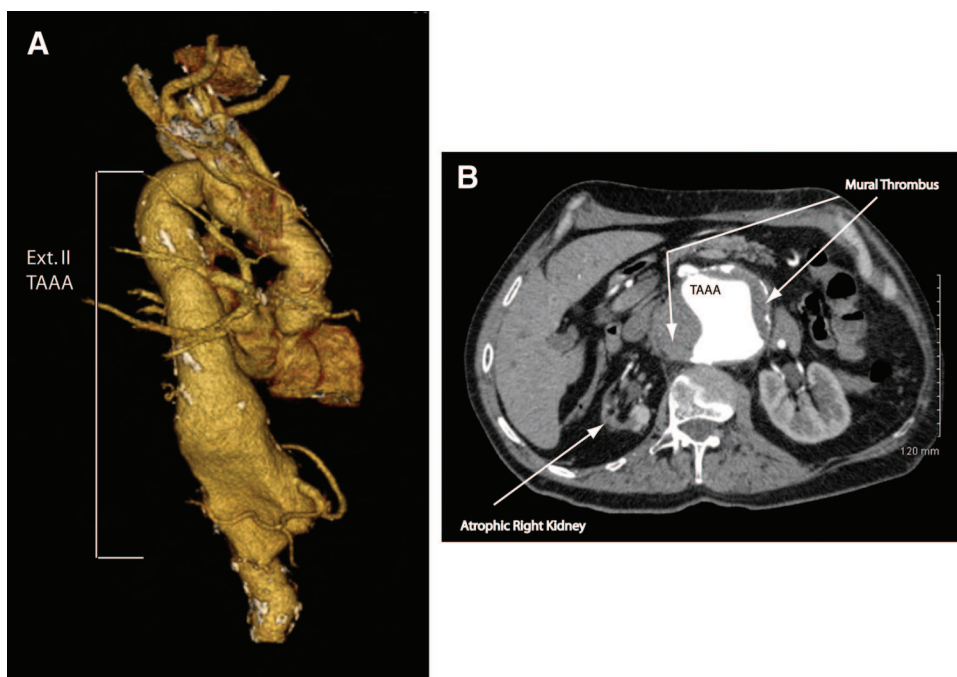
Three-dimensional reconstruction (A) and axial contrast enhanced computed tomography image (B) of thoracoabdominal aortic aneurysm. Note the aneurysm is lined with thrombus and the right kidney is severely atrophic (arrows). TAAA = thoracoabdominal aortic aneurysm.
